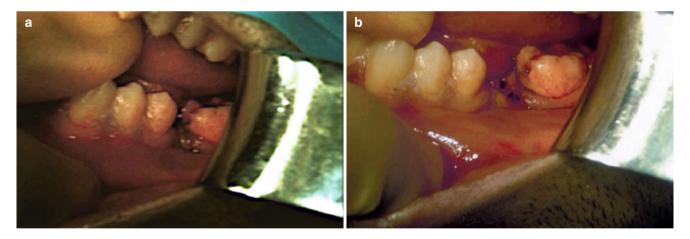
Fracture mobility cannot be determined on a radiograph—the patient must be carefully examined. Although a fracture may appear to be minimally displaced, it can still move. Significant movement such as shown here (a, b) needs support (IMF or ORIF)
